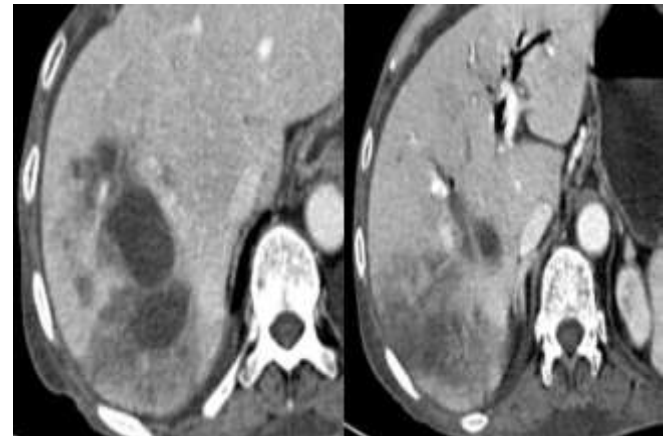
Delayed-phase contrast enhanced CT scan shows a large, hypoattenuating lesion in the right hepatic lobe with thin peripheral enhancement and surrounded by other smaller hypoattenuating areas (arrows). These smaller abscesses cluster or aggregate in a pattern that suggests coalescence into a single large cavity. Air within the bile ducts can be seen. A case of Pyogenic Liver Abscess.
